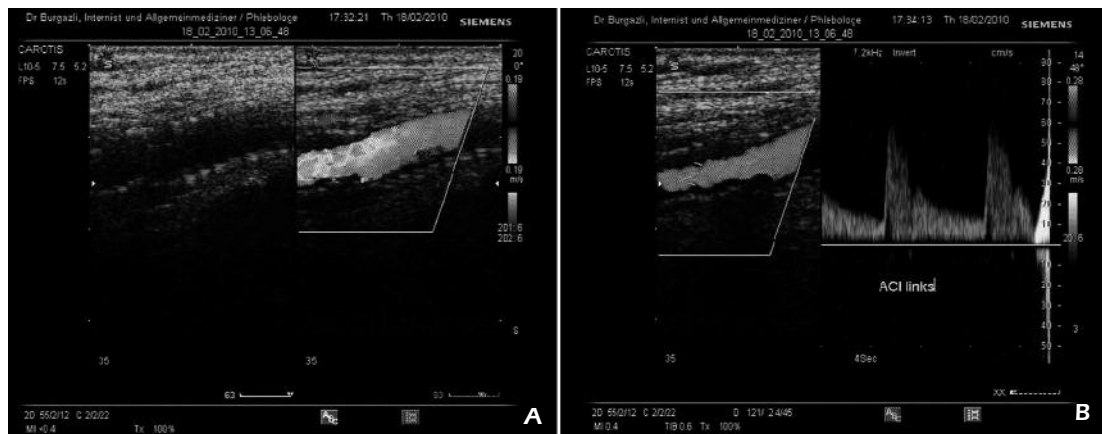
A-B, Doppler and duplex ultrasonographic images of the left ACI after stent implantation.
